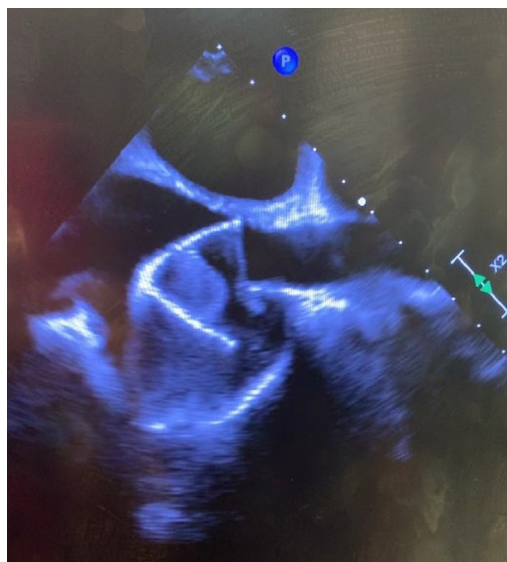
Transesophageal Echocardiogram Visualizing the Snare Device Capturing the Right Atrial Mass
